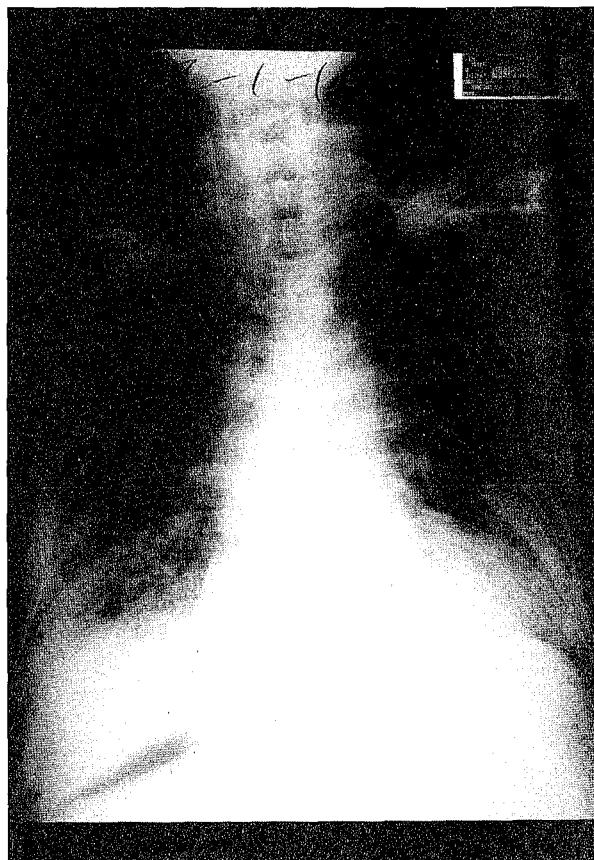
Chest radiograph performed 18 days before death showed multiple patchy haziness in the bilateral lung fields, and a honeycombing change in the bilateral lower lobes.
